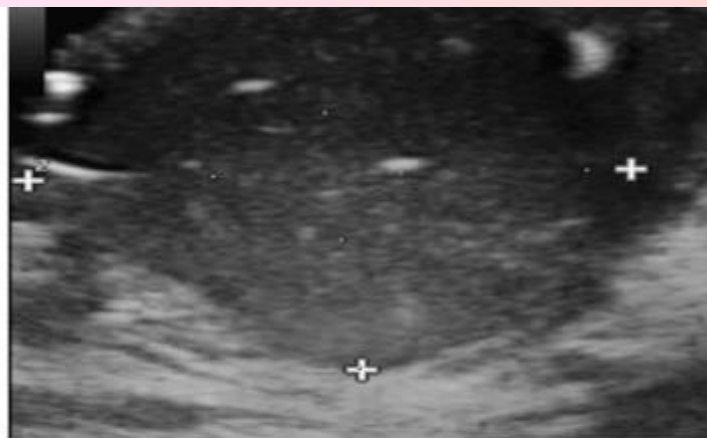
Ultrasonography shows a 15 \times 16mm well-circumscribed, heterogeneous, oval lesion located in the dermis and subcutaneous tissue.
